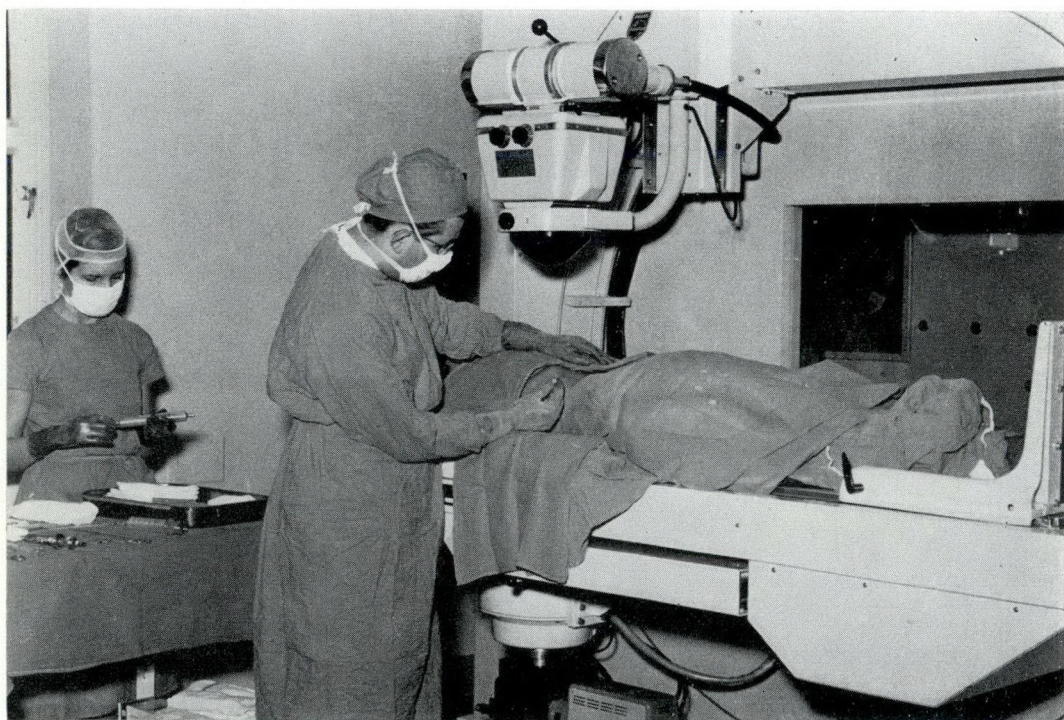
This picture shows x-ray equipment needed and stresses the importance of aseptic technique.
